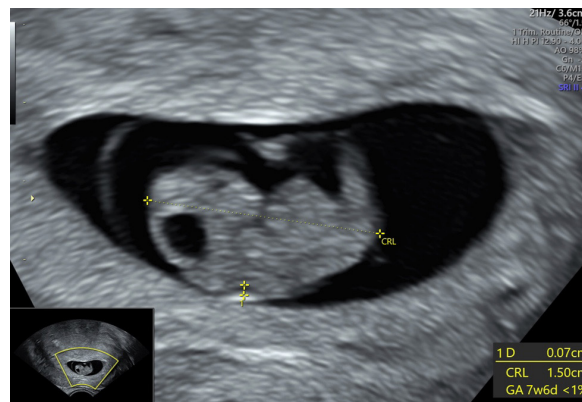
Fetal ultrasound image demonstrating nuchal translucency at 7w^{+6d} of gestation.
